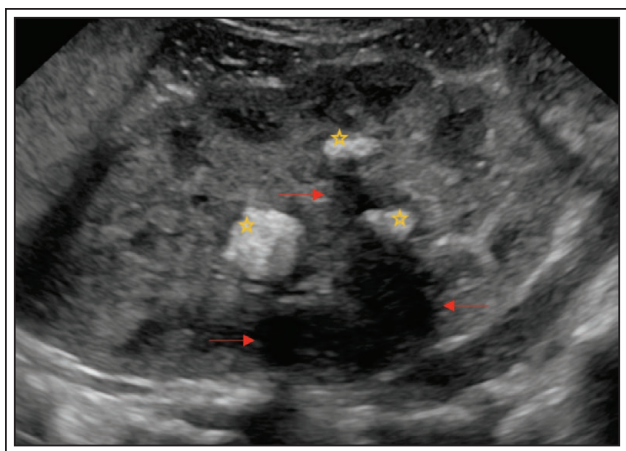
Renal ultrasound obtained at five weeks of life demonstrating multiple new large non-obstructing stones in her solitary kidney. (Star indicating hyperechoic foci with red arrows pointing out posterior acoustic shadowing).
